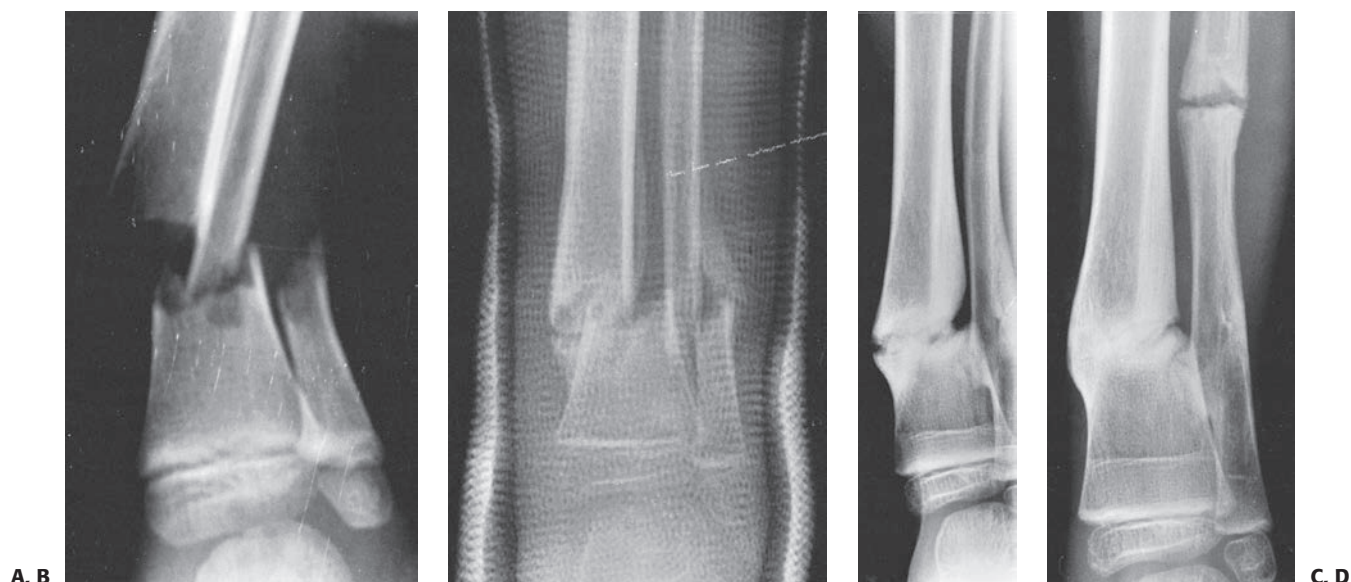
A: Anteroposterior radiograph of the distal tibia and fibula in a 5-year-old boy with an open fracture. B: Early callus formation is seen 1 month after injury. C: The tibia has failed to unite 10 months after injury. D: The patient underwent a fibulectomy 4 cm proximal to the tibial nonunion. The tibial fracture united 8 weeks after surgery.
